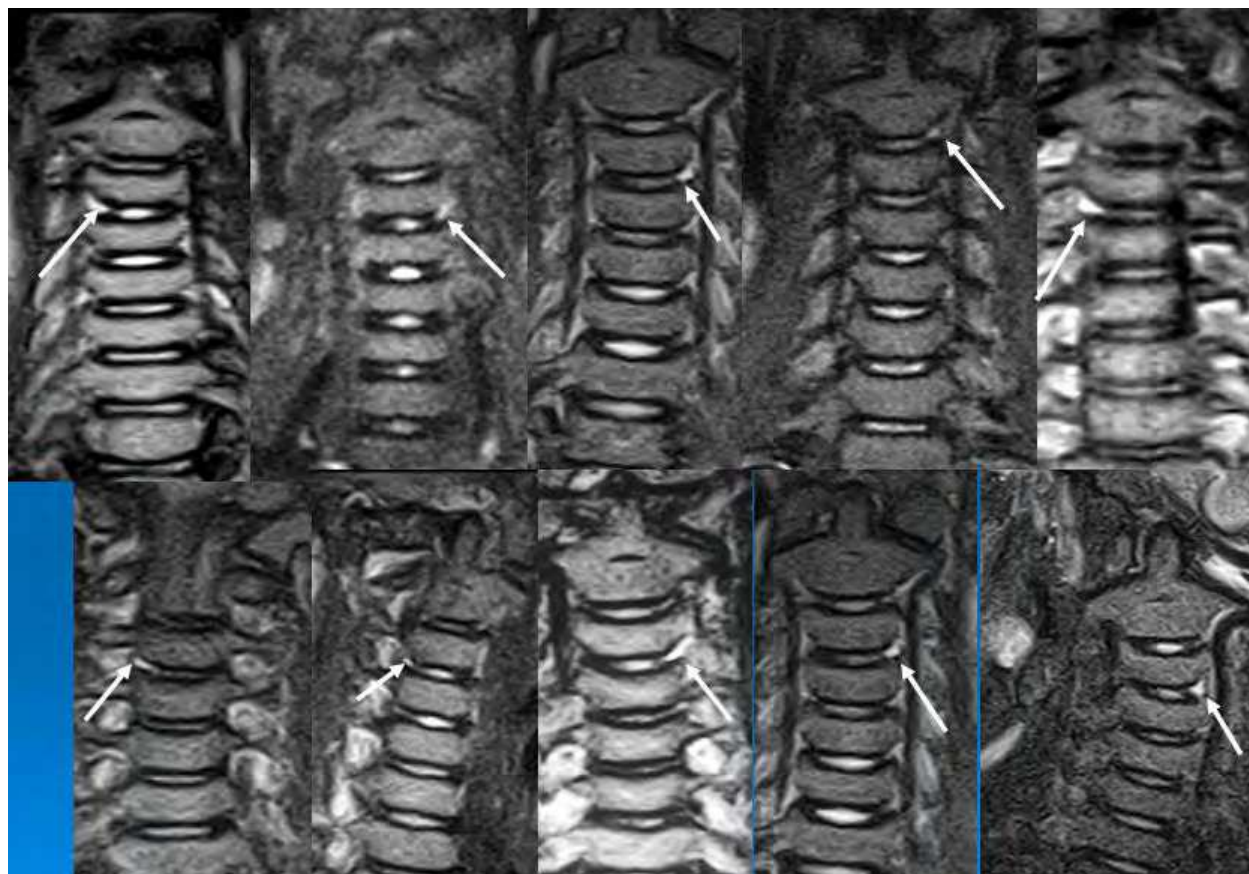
MRI in the fat inhibition mode in 10 children with acute torticollis. The triangular area of hyperintense signal is clearly seen in posterior-lateral parts of intervertebral space. The disk outline is separated from this area.
